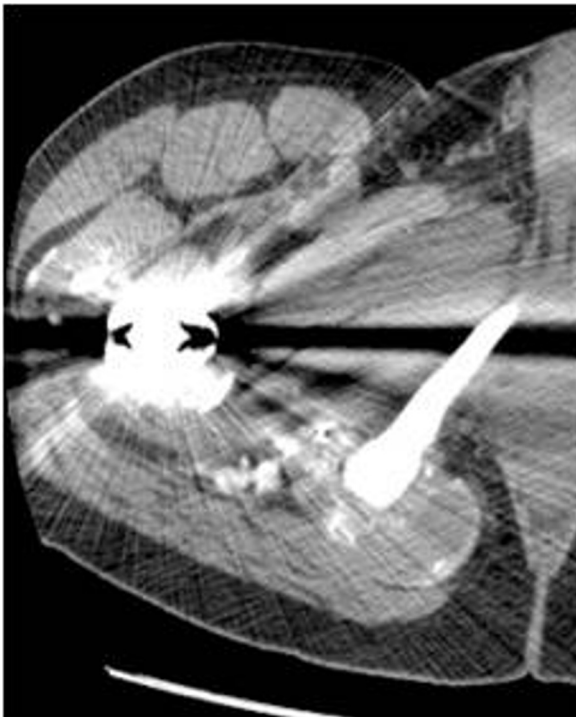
50-year-old man with extensive metallosis. Non-contrast CT of the right hip joint, at the level of the inferior pubic ramus, shows several round, fluid-density collections with high-density peripheral rims, which are located both anterolaterally and posteromedially along the capsule of the right hip joint. Artifact from right hip prostheses is also present.
